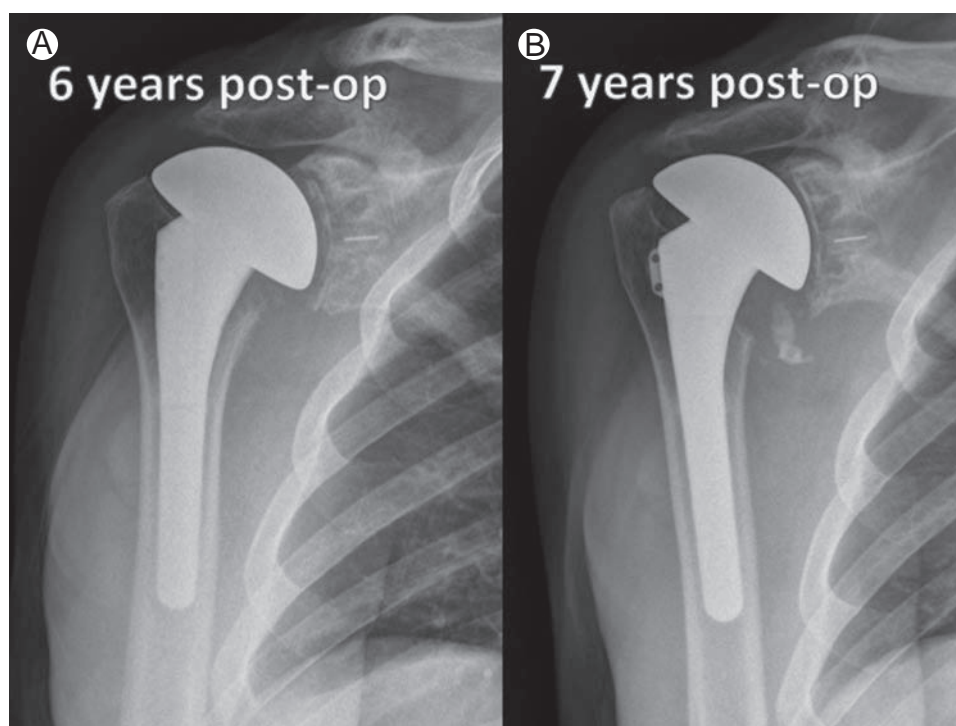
Sequential radiographs of an infected total shoulder arthroplasty, which demonstrate progressive humeral osteolysis most prominent in the inferomedial calcar (A) at 6 years and (B) at 7 years.
